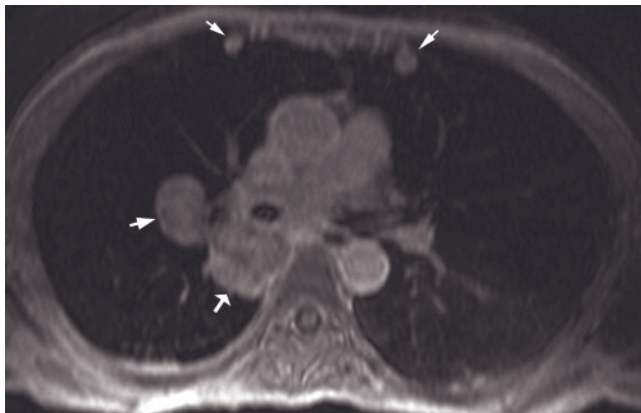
Primary lung cancer. T2-weighted ETSE (a) and postgadolinium fat-suppressed 3D-GRE image (b) in a patient with lung cancer (arrows, a, b); T1-weighted postgadolinium fat-suppressed 3D-GRE images (c, d) in a second patient show primary
